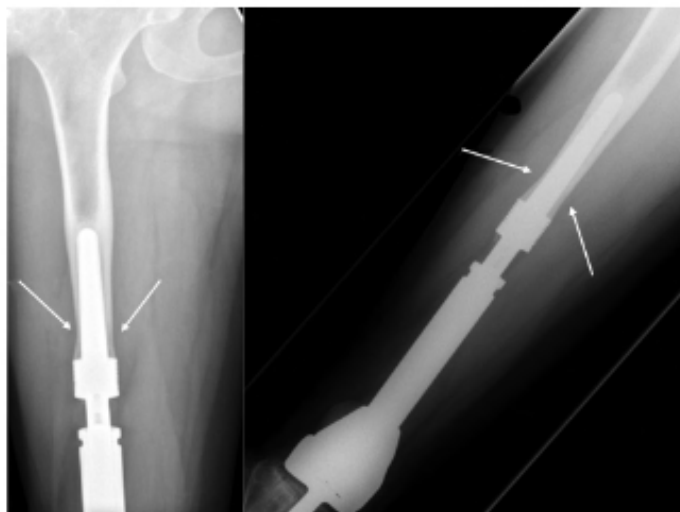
Radiograph showing cortical remodelling of a well-fitted distal femoral replacement 24 months post-operatively in a 24-year-old male. Arrows show the 'hour glass' appearance.
